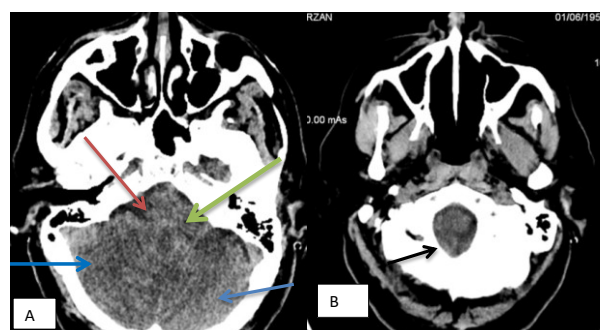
Cranial CT scan A. Hypodensity in the PICA territory of the right cerebellar hemisphere and left cerebellar hemisphere, left vertebral artery ischemia-blue arrow. Hypodensity in the vermian territory-green arrow. Completely compressed fourth ventricle (red arrow) B. Cerebellar tonsillar hernia, predominantly right-black arrow NB Due to the very serious clinical and neurological condition, I did not have the time necessary to obtain a preoperative brain MRI.
